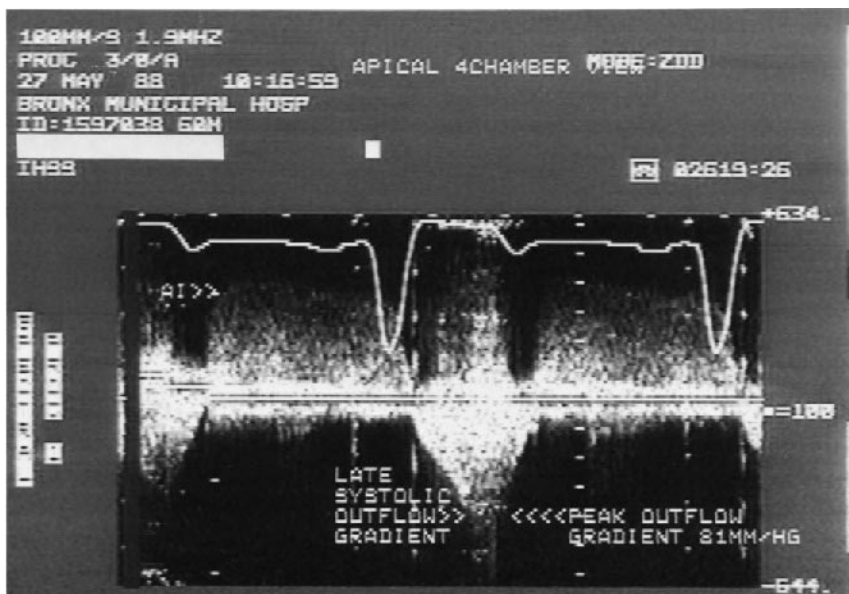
Continuous-wave Doppler recording obtained in the LV outflow tract of an elderly patient with obstructive hypertrophic cardiomyopathy. Note the increased late-systolic LV outflow tract velocity, which translates to a peak LVOT gradient of 81 mmHg. In diastole, a characteristic aortic insufficiency velocity pattern is noted.
